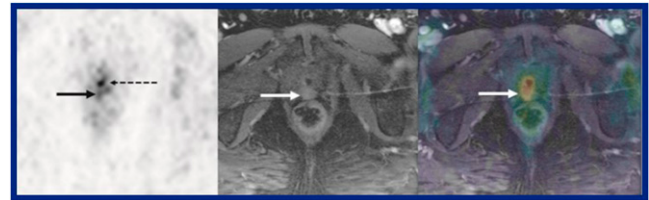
Contribution of multiparametric pelvic and whole-body MR to interpretation of ^{18}F -fluoromethylcholine or ^{68}Ga -HBED-CC PSMA-11 PET/CT in detection of pelvic recurrence or distant metastases in patients with biochemical failure following radical prostatectomy. Interpretation of PET with multiparametric MR results showed a higher detection rate for local tumor recurrence in the prostate bed. However, the addition of whole-body MR to ^{18}F -fluoromethylcholine/ ^{68}Ga -HBED-CC PSMA-11 did not improve detection of regional or distant metastases. Images of axial PSMA PET/multiparametric MR, with left image (PSMA PET) showing intense radiotracer activity in urethra at level of surgical anastomosis (dotted arrow) and ill-defined moderate uptake posterior to the urethra, not interpreted prospectively as tumor on PET. Fused PET/MR image (right) shows the radiotracer uptake corresponds to a focus of abnormal enhancement on dynamic contrast-enhanced MR (arrow, middle and right), suggestive of local tumor recurrence.
